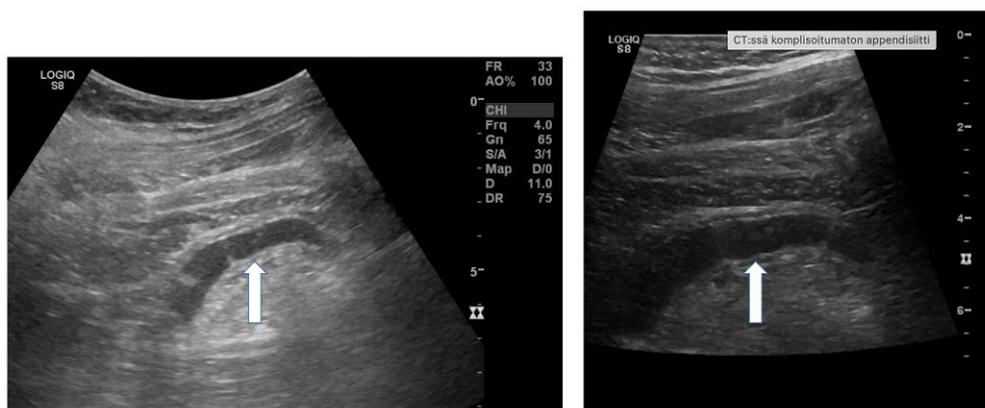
Ultrasound images of uncomplicated acute appendicitis. A noncompressible distended appendix is seen.
